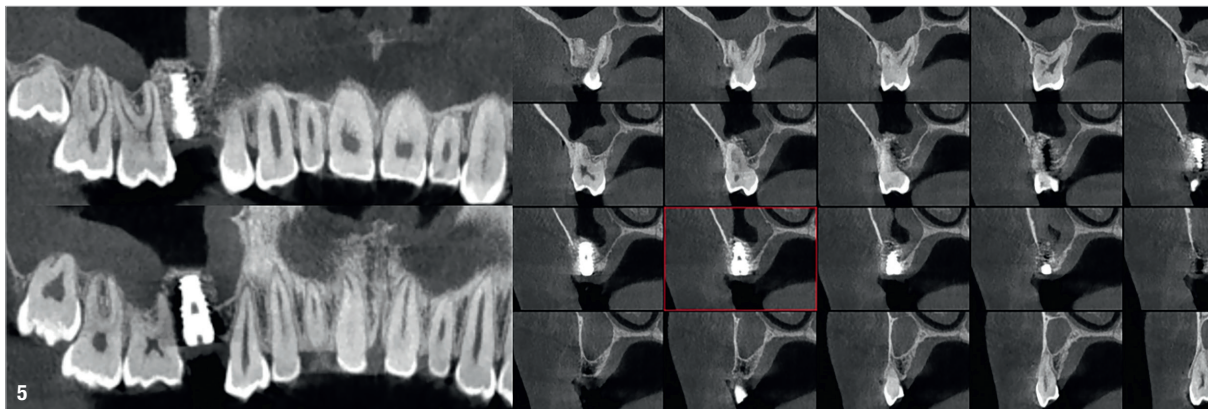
Final CT scan with coronal and sagittal sections.
